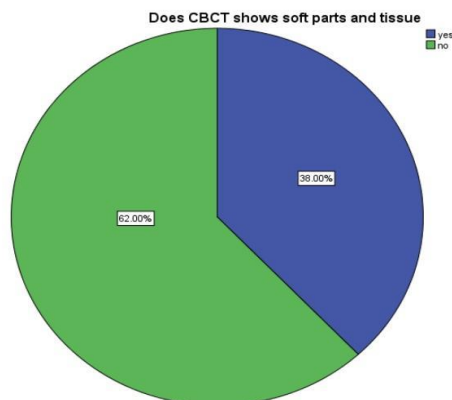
Pie chart shows the response of the participants about CBCT showing soft parts and tissue. In that 62% said no and 38 % said yes . Blue colour indicates yes and green colour indicates no
